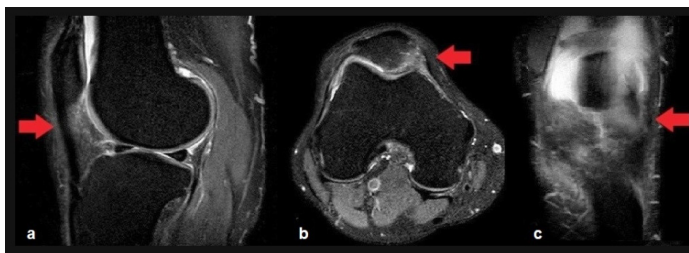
34-year-old man with anterior knee pain for 4 months. Sagittal (a), axial (b), coronal (c) fat-suppressed proton density-weighted images of the left knee magnetic resonance imaging showing increased focal signal to the superolateral of the infrapatellar fat pad (red arrows).
